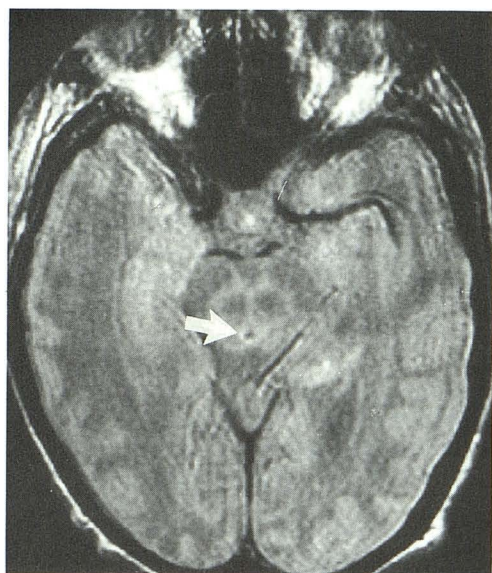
Proton-density MR image (2200/30) from November 1991 shows dilatation of the aqueduct with decreased but persistent signal abnormalities in the midbrain. Motion artifacts are present.
